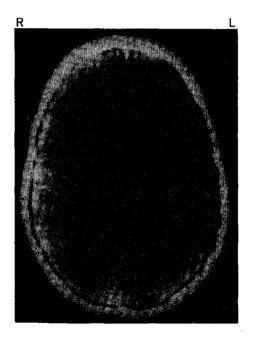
Patient 3. Computed tomographic scan five days after onset, demonstrating a small, mixed density contusion (arrows) in the left temporal lobe behind the sylvian fissure.
